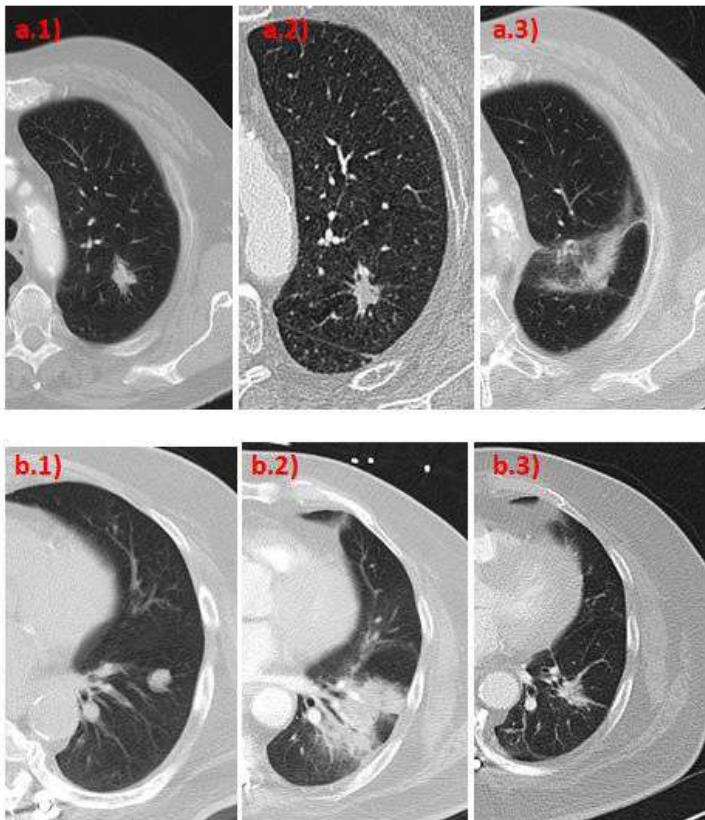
Axial CT images a.1) Pre-treatment a.2) 6 months and a.3) 2 years follow-up CT scans for the same patient. This patient received $V300GyBED=31cc$ in a left upper lobe pulmonary nodule, and late changes in the parenchyma can be seen with organizing pneumonia-like changes. b.1) Pre-treatment CT scan b.2) 6 months and b.3) 2 years follow-up CT scan for the same patient. This patient received $V300GyBED=0cc$ in a left lower lobe pulmonary nodule, showing late changes with a consolidation pattern at 6 months follow up CT, with radiological improvement at 2 years.
